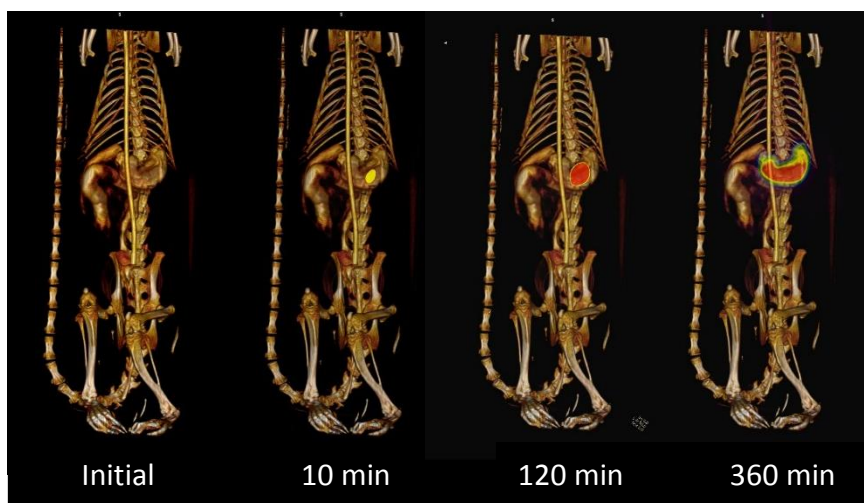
Fused image PET/CT. a) Prior to the administration of the Klucel device b) 10min c) 120min and d) 360min post-administration.
